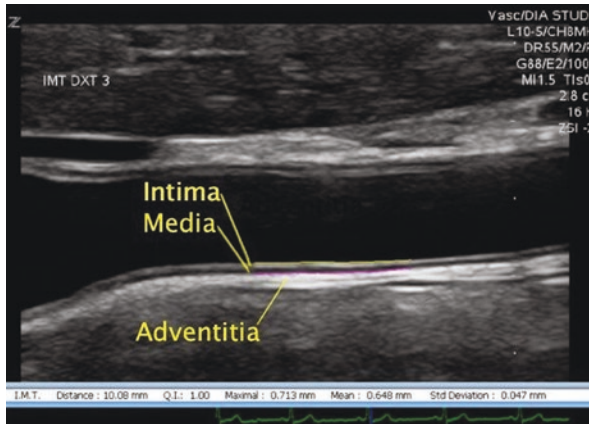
Two-dimensional ultrasound imaging to assess carotid intima-media thickness (CIMT). Intima-media complex in the CCA. The figure shows the distal 2 centimeters of the CCA. Intima, media, and adventitia are indicated as well as the 1-centimeter area in which CIMT is measured. Abbreviations: CCA common carotid artery, CIMT carotid intima-media thickness. (Reprinted from Gaarder and Seierstad [85]. With permission from Creative Commons License 4.0: <https://creativecommons.org/licenses/by/4.0/>)
